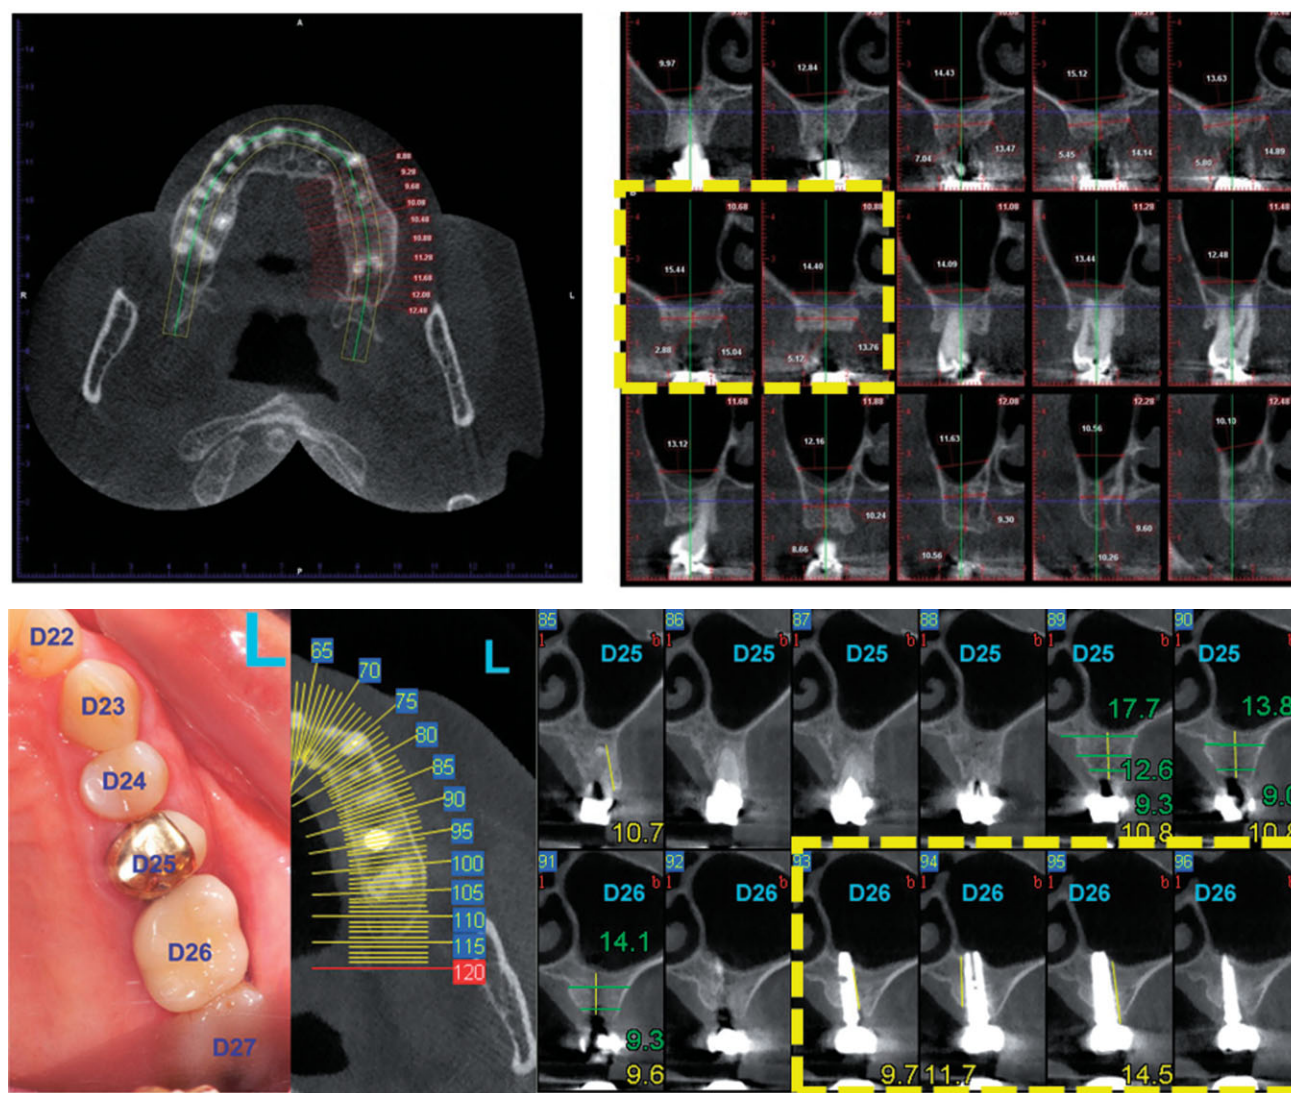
Top: preoperative Cone Beam Computed Tomography (CBCT) images – implant location marked by yellow outline. Bottom: CBCT images after final restoration, 19 months postoperatively.
